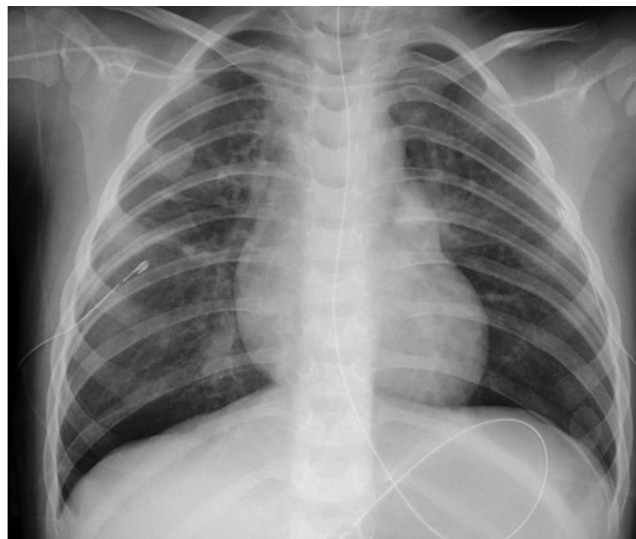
Chest x-ray after bilateral tube thoracotomy reveals inflated lungs and improved heart size
